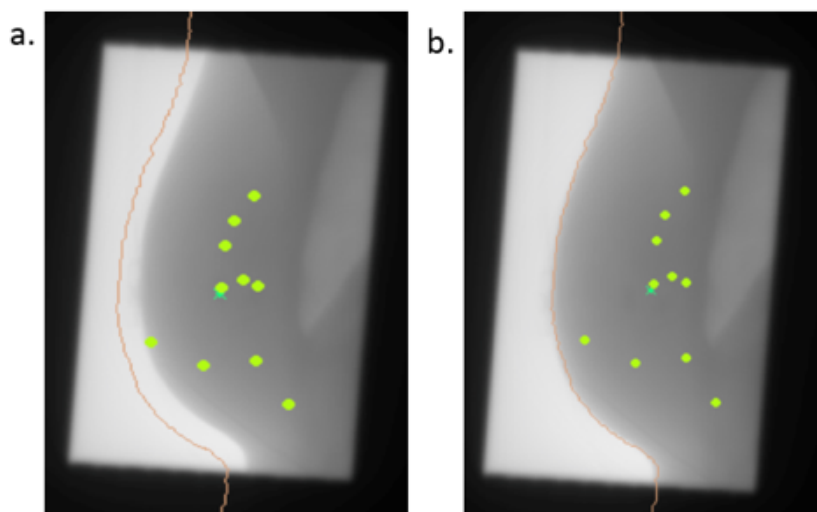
a. Misalignment between planning CT breast contour and breast contour on EPID image. b. Alignment of patient breast contour and EPID image breast contour following contour matching correction.
